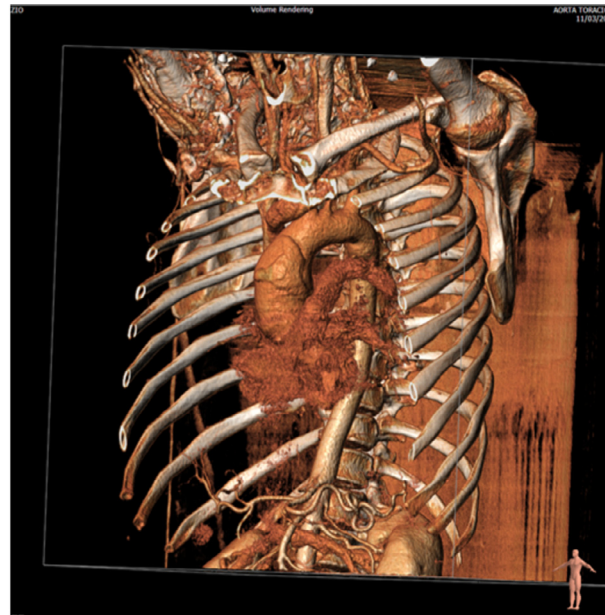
CT scan images. CT scan of the aorta shows 3-dimensional image reconstruction of thickened aortic wall originating from the sinotubular junction, ascending portion with a maximum diameter of 45 mm, without involvement of the epi-aortic arterial branches. Without involvement of arch of aorta. Ascending aortic dissection and thickened aortic wall with pericardial and pericardial effusion. No pulmonary alteration in progress. CT, computed tomography.
